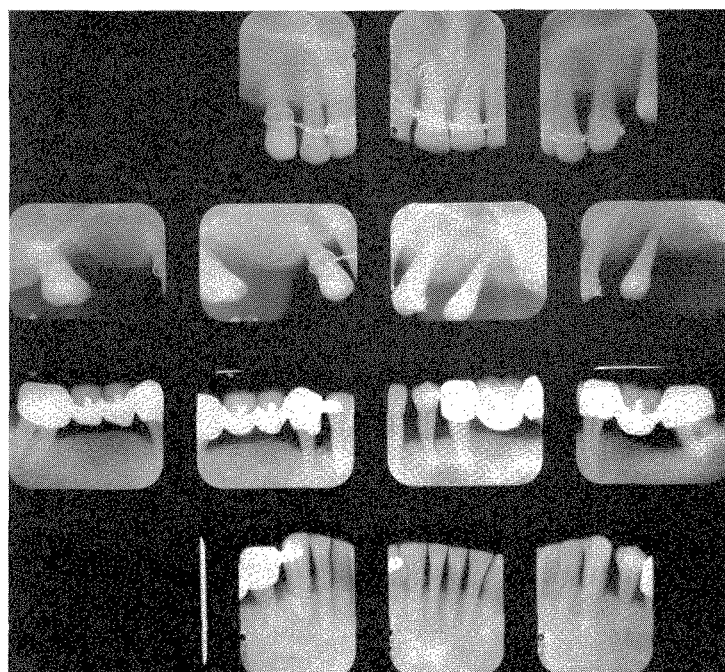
Roentgenograms taken in October, 1956, before the work was started.
